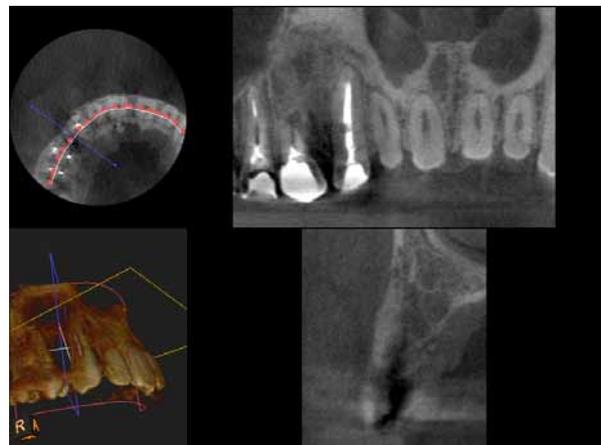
Cone Beam Computed Tomography imaging confirmed regeneration of bone structure.
